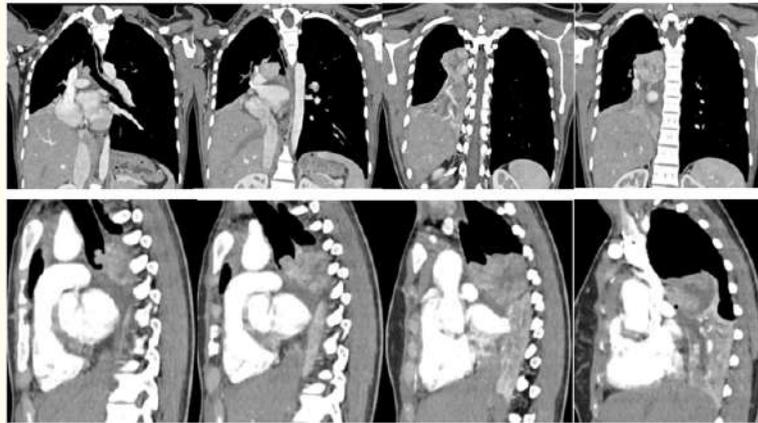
Reconstructed Coronal (A-D) and Sagittal (E-H) Contrast enhanced Computed Tomography images reveal multilobulated endotracheal and right endobronchial tumour occluding the right main bronchus.
